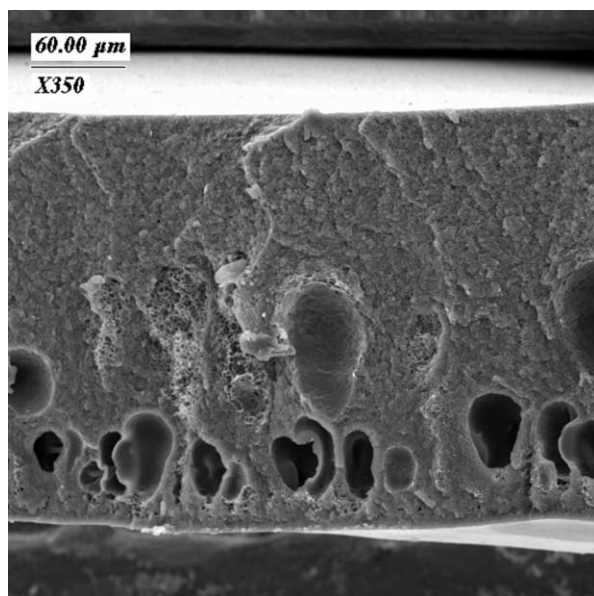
SEM of cross-section of coagulated CDA, at 350 \times magnification. The lower surface of the cross-section was initially in contact with the cover slip during the MRI experiment.
